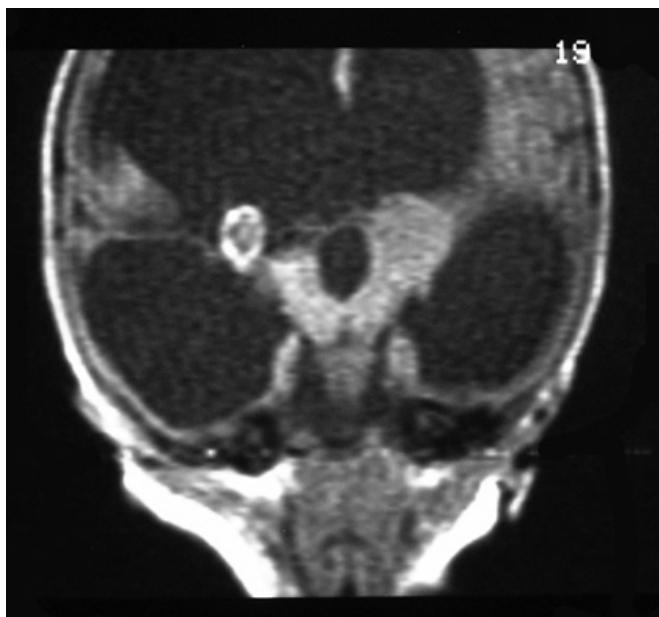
The coronal view of T1-weighted image from the pre-operative brain MRI confirms a heterogeneous mass on the place compatible with the right MCA bifurcation.
